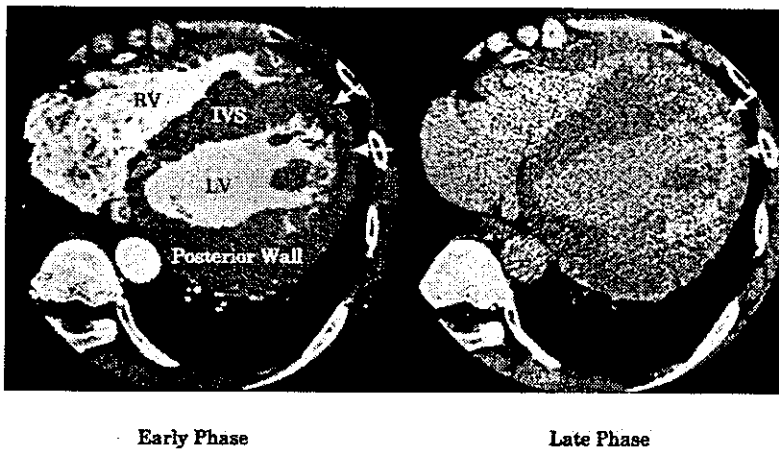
Axial source images of enhanced multislice computed tomography acquired 30 seconds (early phase) and 8 minutes (late phase) after the injection of the contrast material. Images show extreme hypertrophy of the interventricular septum (IVS) and posterior wall compared with the apical and lateral walls of the left ventricle (LV). The apical and lateral portions revealed lower computed tomography intensity than the IVS in the early phase (arrows). Conversely, in the late phase, the apical and lateral portions of the LV (arrows) were abnormally enhanced compared with the extremely hypertrophic IVS, suggesting more fibrotic changes in the apical and lateral myocardium. RV indicates right ventricle.
